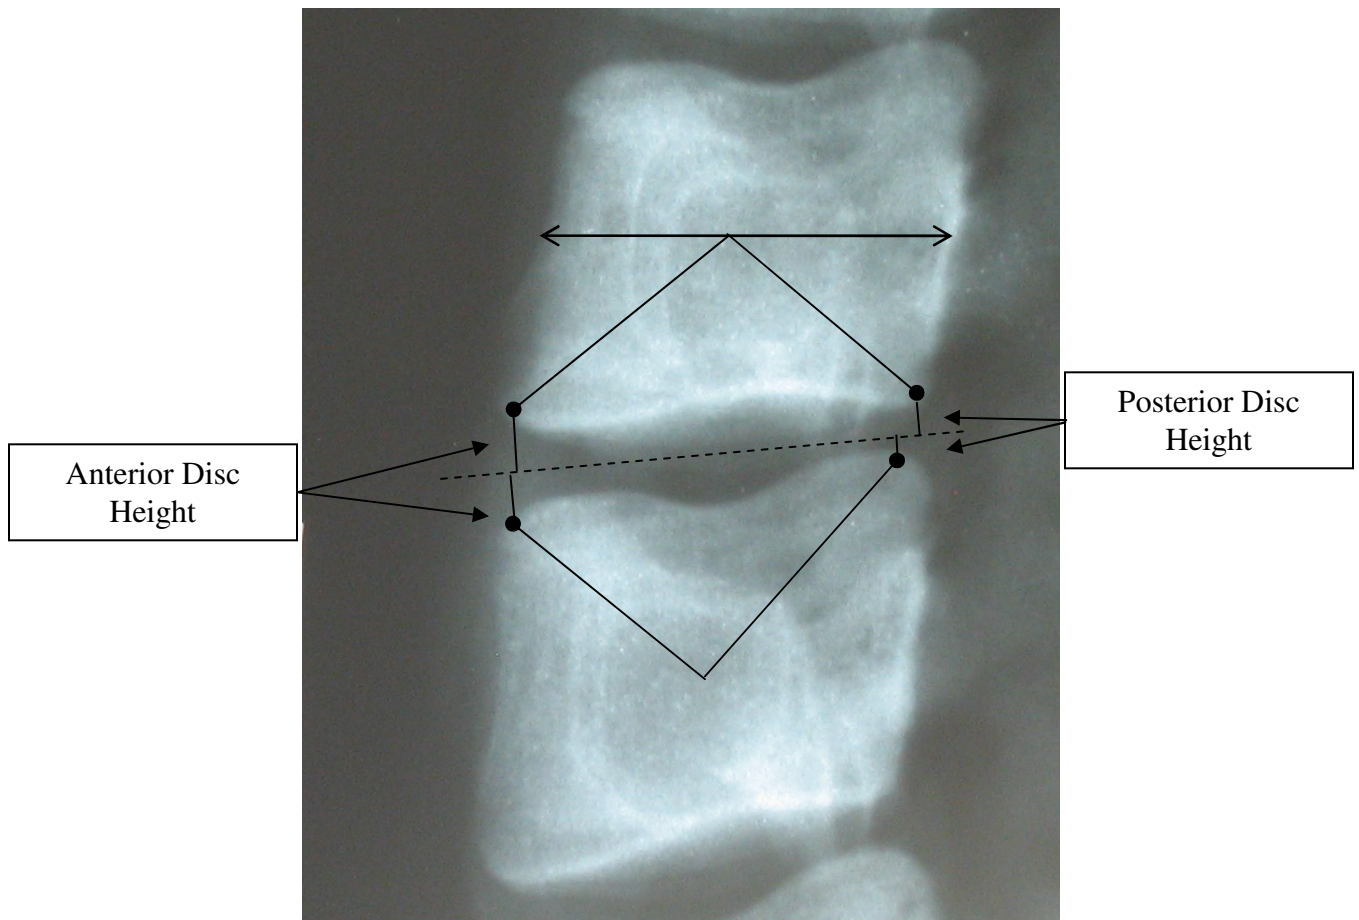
Wilke et al (2006) calculated anterior disc height as the sum of the perpendicular distances from the anterior edges of the superior and inferior vertebral bodies (anterior black dots) to the midplane of the disc (dashed line). The edges of the vertebral bodies were identified as the points that were furthest from the center of the vertebral body. Posterior disc height was calculated as the sum of the distances from the posterior edges of the superior and inferior vertebral bodies (posterior black dots) to the midplane of the disc. Both in Wilke et al (2006) and in the current study the disc height was measured directly from the lateral x-ray images by each observer. Wilke et al (2006) expressed disc height as a percentage of the normal values reported by Frobin et al (1997). In the current study disc height loss was expressed as a percentage of the pre-test disc height (post-preload) and the anterior and posterior disc height loss were averaged to give one figure for disc height loss.
